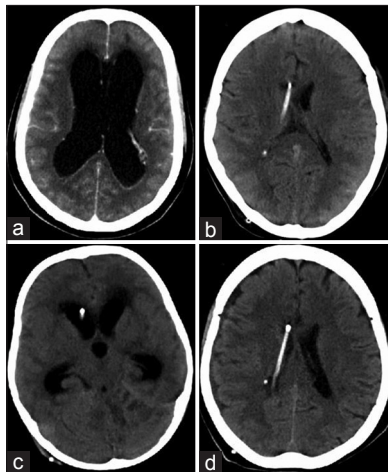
(a-d) Pre- and post-operative computed tomography scans of a 20-year-old lady with tuberculous meningitis and subsequent shunt malfunction
